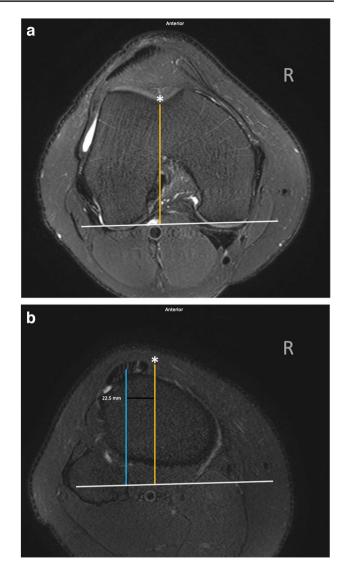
TT-TG. Axial T2-weighted MRI of a right knee demonstrating (a) the measurement between the deepest point of the trochlear groove (asterisk along the yellow line) along a line parallel to the posterior condylar axis (white line) superimposed with (b) the center of the tibial tuberosity (blue line). TT-TG values greater than 20 mm are considered abnormal
